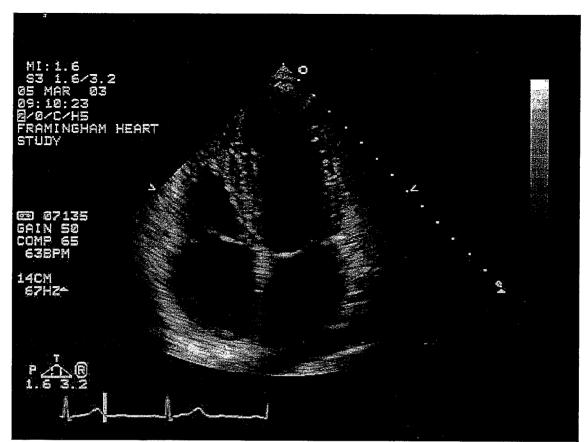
Example of 2-D Apical Four-Chamber view. All four chambers are showing well and on-axis; clear wall definition, mitral valve as well as tricuspid valve are showing well. Septum is in a vertical line and the entire heart is on-axis (optimal image)
